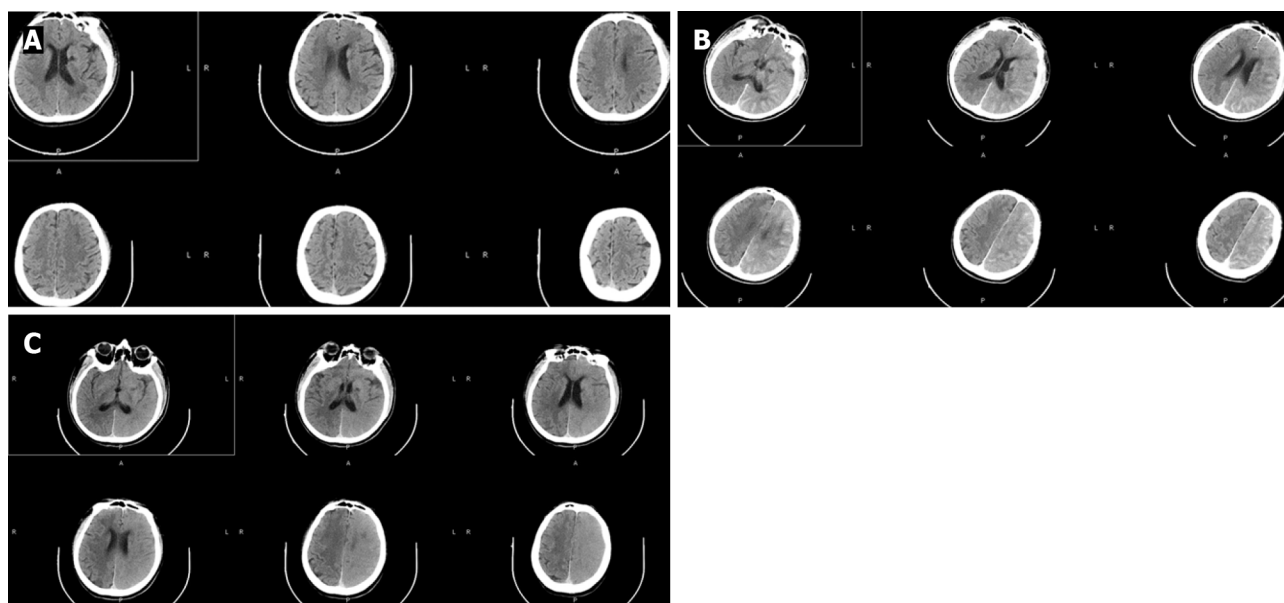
Computed tomography of the brain before and 2 h and 7 h after the procedure. A: The normal occipital lobe of the left cerebral hemisphere on the preprocedure computed Tomography (CT); B: The increased density of the interhemispheric cistern, left fissure cistern and part of the left sulcus on CT 2 h after digital subtraction angiography (DSA); C: Seven hours after DSA, indicating the swelling of the left frontal, temporal, parietal and occipital lobe brain tissue, the disappearance of the high-density shadow of sulci and gyri, the shallow appearance of the sulci and gyri, and the higher density of the left cerebral hemisphere than the right cerebral hemisphere.
